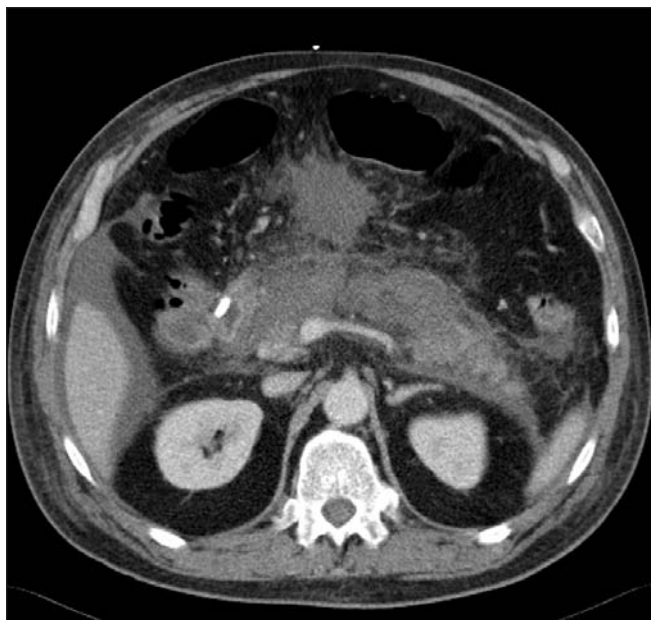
A contrast-enhanced CT scan at the level of splenic vein. The pancreatic head demonstrates heterogeneous enhancement with peripancreatic fat stranding and the pancreatic neck and body are replaced by a complex collection of non-enhancing tissue. Findings are consistent with phlegmonous pancreatitis with pancreatic necrosis.
